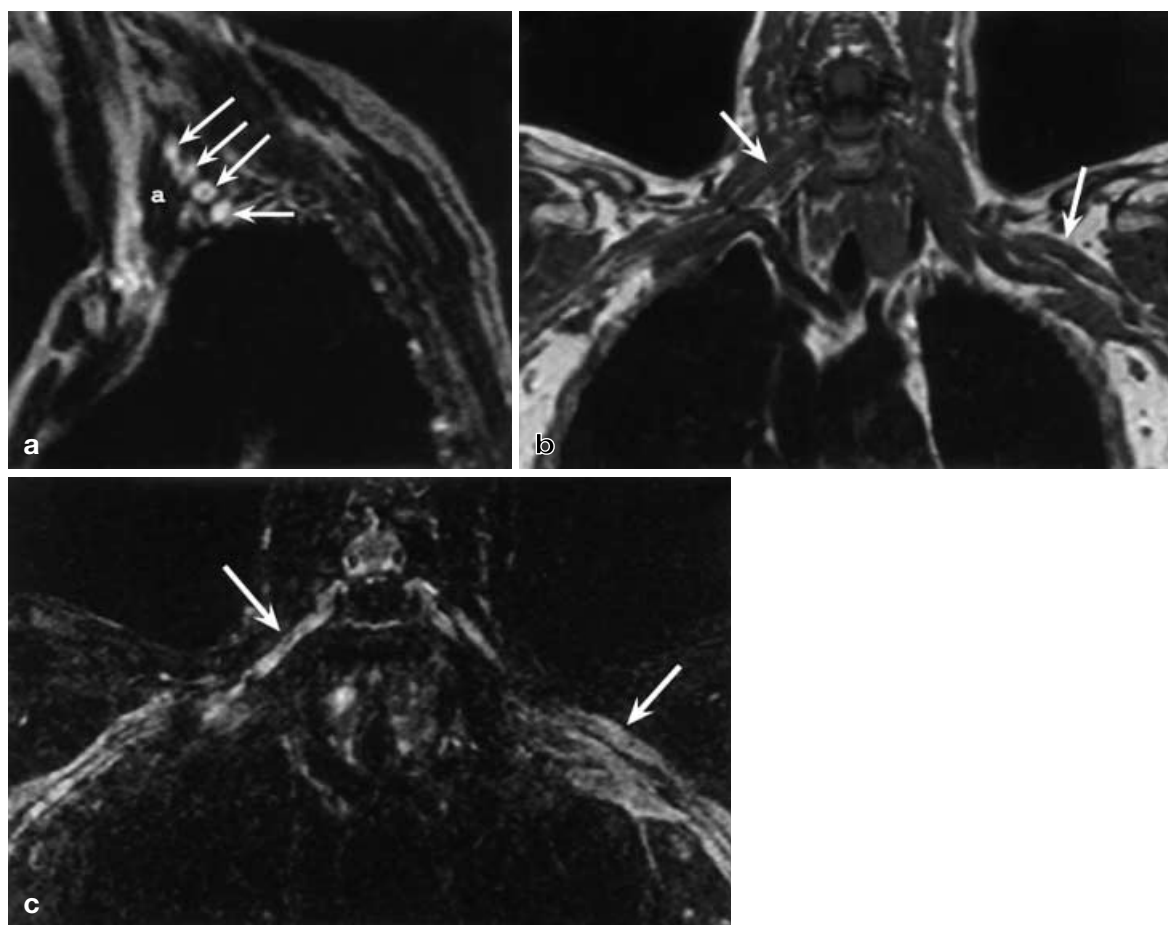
A patient with CIDP. a Sagittal T2-weighted image at the level of the interscalene triangle shows an increased signal intensity of the ventral rami of the nerve roots (*arrows*). a anterior scalene muscle. b Coronal T1-weighted and c T2-weighted STIR image show a slightly thickened brachial plexus on both sides with an increased signal intensity on the STIR image (*arrows*)
